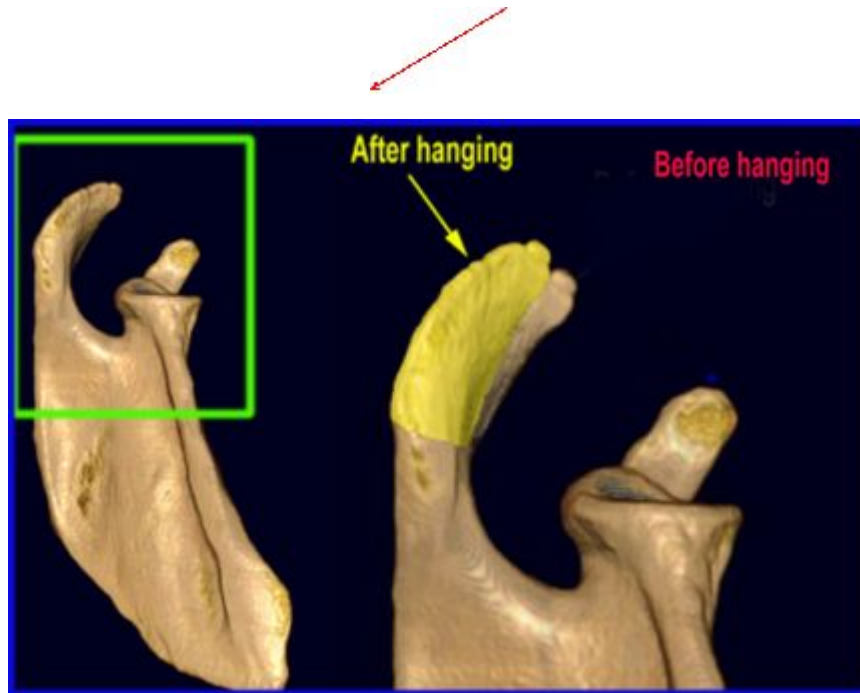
A view from the side of the shoulder in the arm at the side (anatomic) position. This is an artist's rendering overlaid on actual CT scan images. One can see that the shoulder anatomy remains intact using the hanging and weight lifting exercise protocol.
